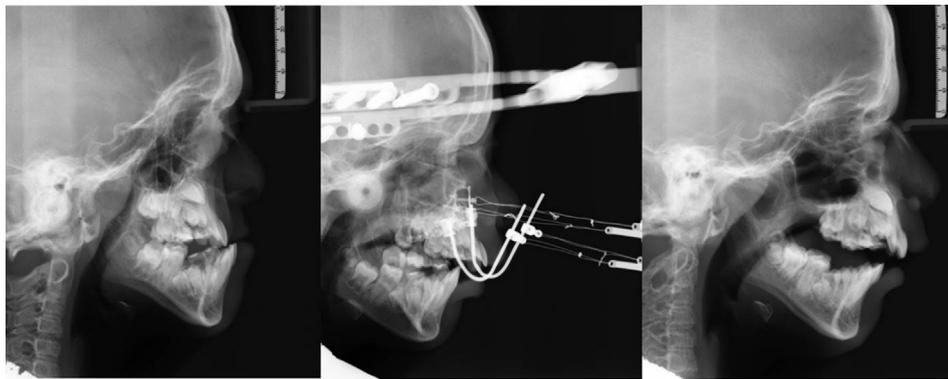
Lateral cephalometric radiographs of patient 1 at three time intervals: preoperatively (T1), at device removal (T2), and at 1-year follow-up (T3).
